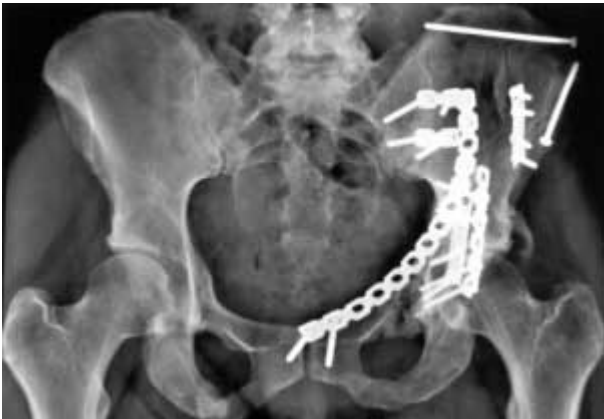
Postoperative x-ray of the pelvis
